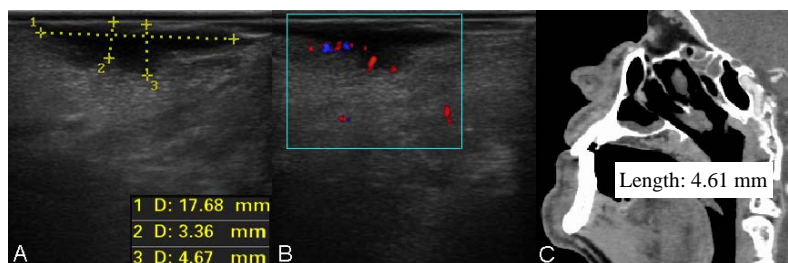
Oral cavity carcinoma (OCC) localized on the ventral side of the tongue with measured DOI and GD: A) A hypoechoic, plaque lesion with an unsharp border towards the deeper tissues of the tongue, shown by the IOUS; B) Visualization of OCC vascularization using IOUS – note the dominantly fringe distribution of Color Doppler signal (blue and red color); C) Contrast-enhanced CT in sagittal reformation with the tip of the tongue on the hard palate showing OCC with measured DOI, localized on the ventral side of the tongue. There is a well-opacified plaque lesion on the ventral side of the tongue. For abbreviations, see Figure 1.
